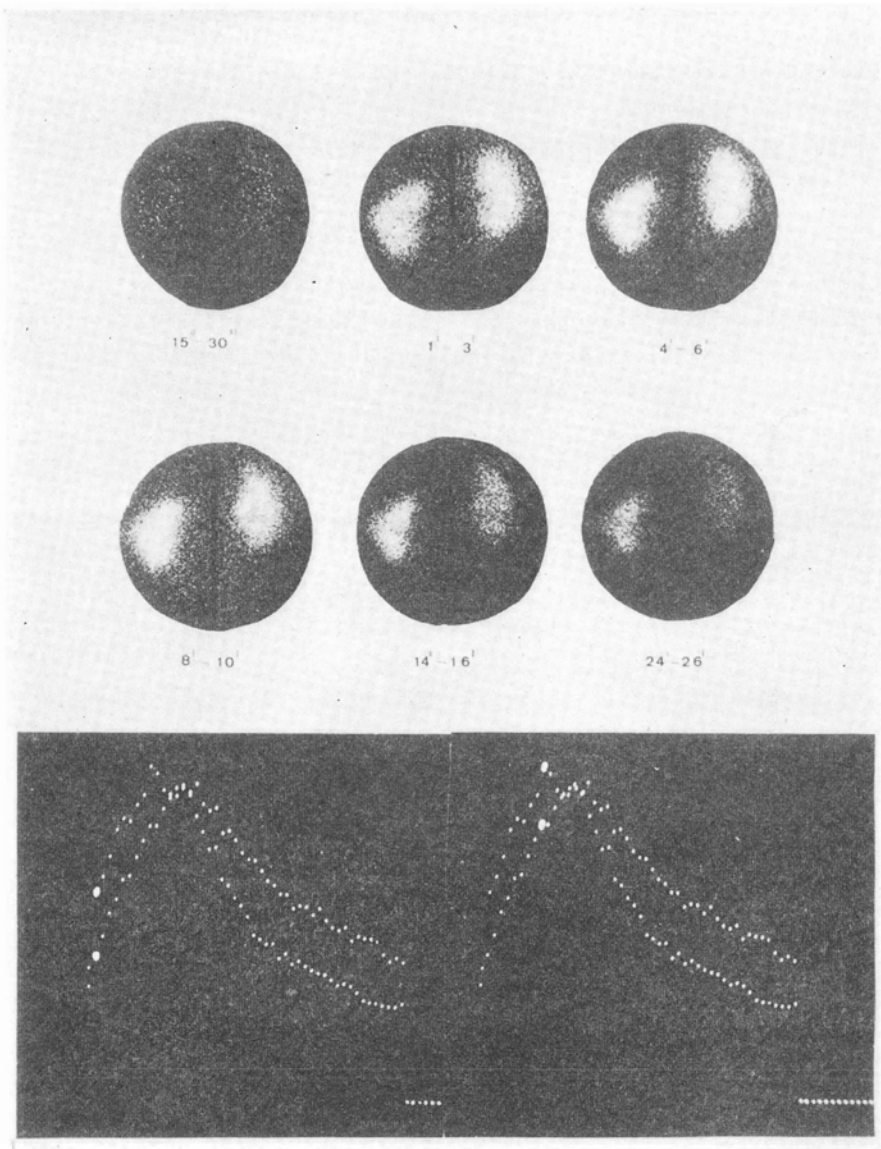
Serial scintigraphy and functional analysis after 500 μ Ci ^{131}I -o-Iodohipuric acid in pyelonephritis of the left kidney: the initial peak is marked, it is reduced on the left side; the marked peak of the right side demonstrates the delayed peak and the delayed evacuation of the left kidney.
